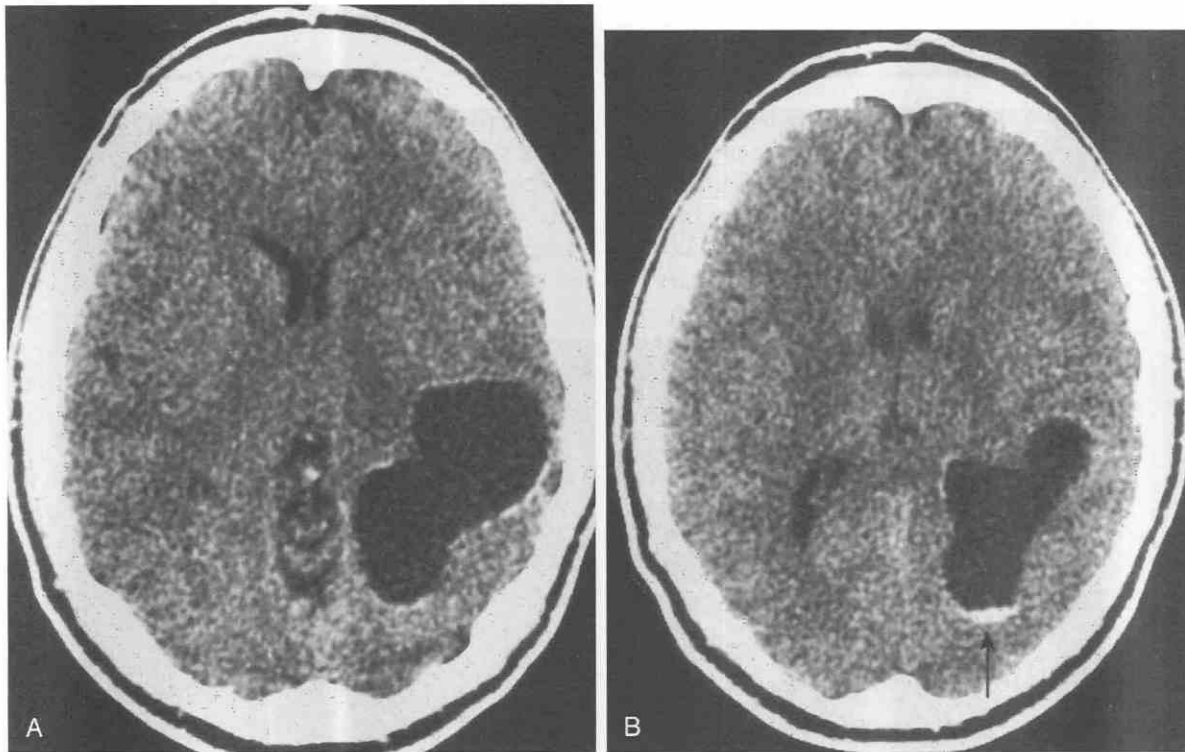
Echinococcosis. A and B, Contrast-enhanced CT scans show a large lobulated cyst with marginal calcification (arrow in B) and minimum cyst wall enhancement.
